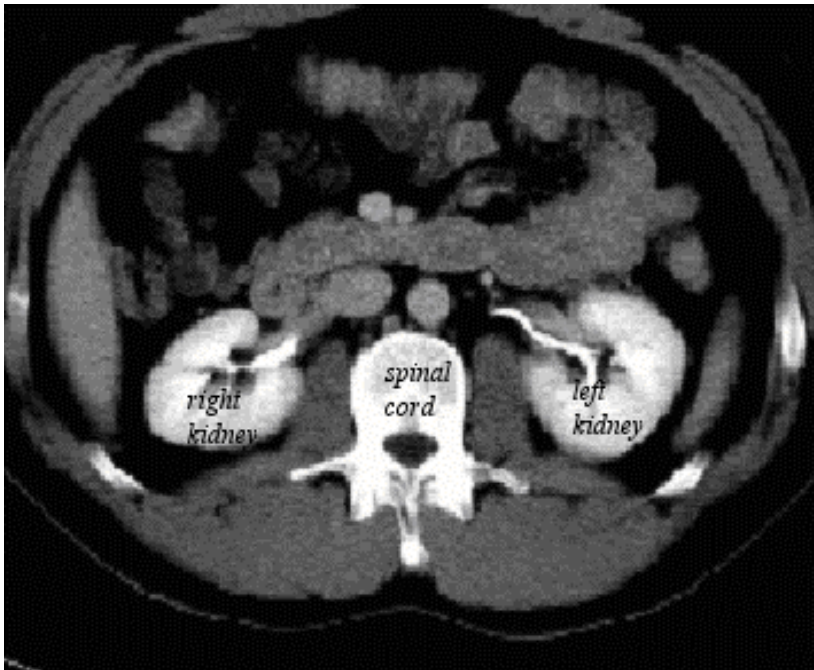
CT image with contrast. Notice that the intensity of the kidney is brighter as compared to the surrounding structures.
